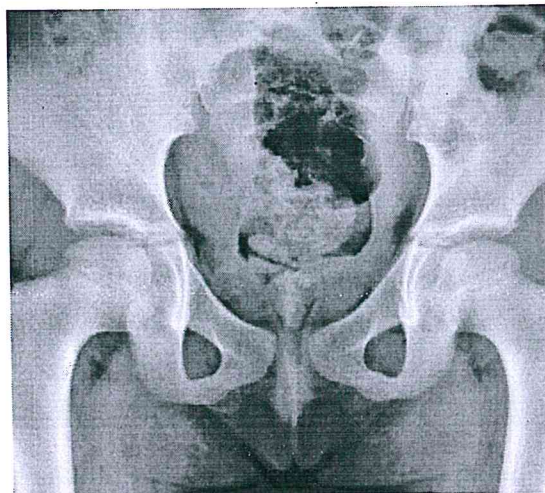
X-ray pelvis shows defect in the symphysis pubis
